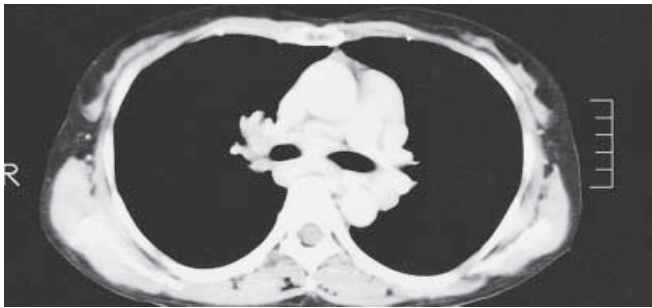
Chest computed tomography scan showing a swelling of the mediastinal and bilateral hilar lymph nodes
